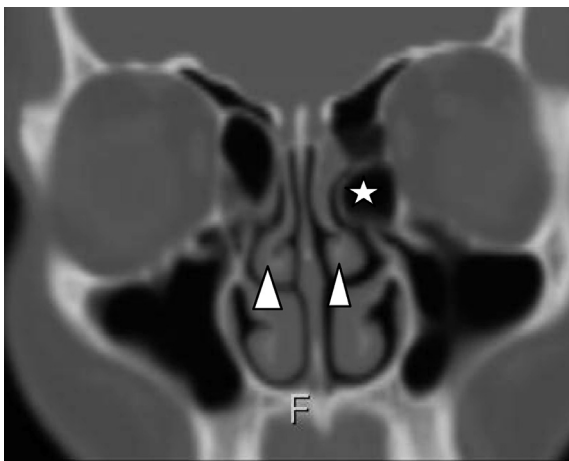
Coronal CT image shows bilateral paradoxical middle turbinate (arrow head) and ethmoid bulla (star).
